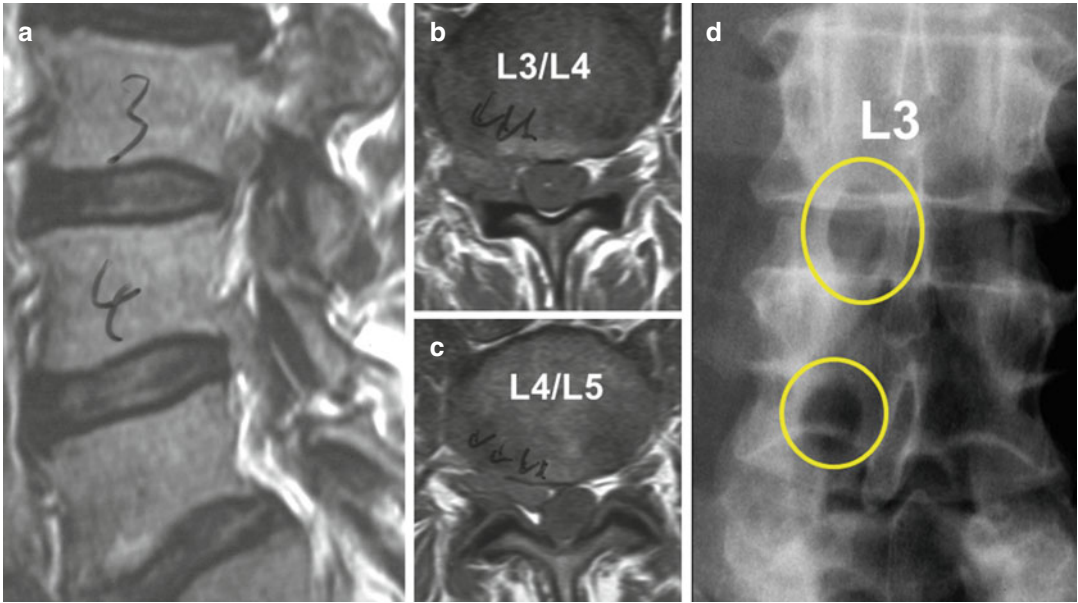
Clinical case: (a) The sagittal MRI shows cranially extruded disk herniations at the level L3/L4 and L4/L5. (b) The DH encroaches the root L3 and (c) L4 on the right side. (d) Because the 28-year-old lady complained about a three-fifth weakness of the m. quadriceps, both
